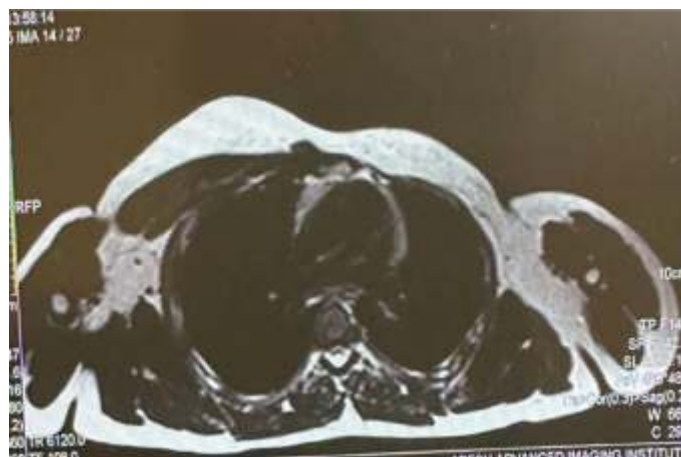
MRI image showing absence of pectoralis major on left side and gynecomastia on right side.
